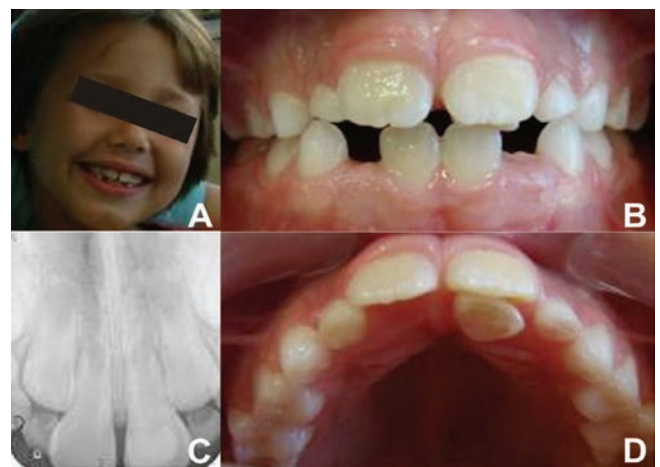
A) Frontal view of the patient's face - twin 02. B) Frontal view of tooth 61. C) Periapical radiography of teeth 11, 21 and 61. D) Occlusal view of tooth 61.
